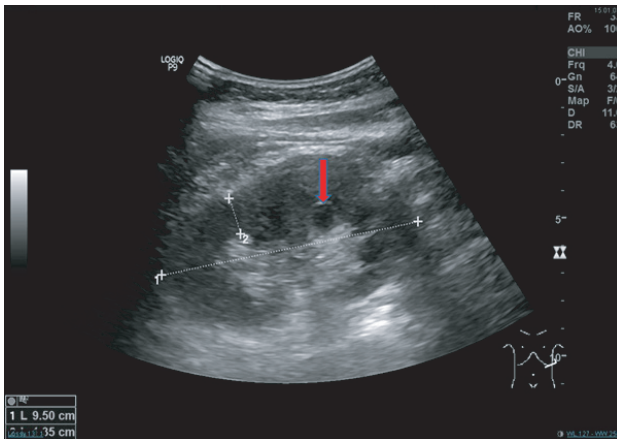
Ultrasound image of the left kidney post renal biopsy. There was small perinephric hematoma measuring 0.8cm x 3.8cm over the lower pole of the kidney. The renal cyst at the lower pole (red arrow) remained the same.
